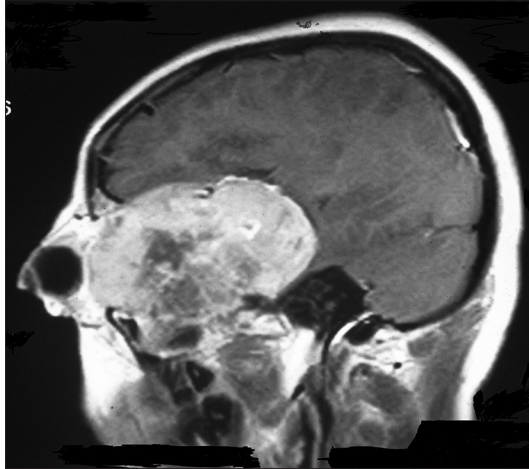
T1-weighted magnetic resonance image with contrast showing a large heterogeneous lesion arising from right orbit with intracranial extension - sagittal view
